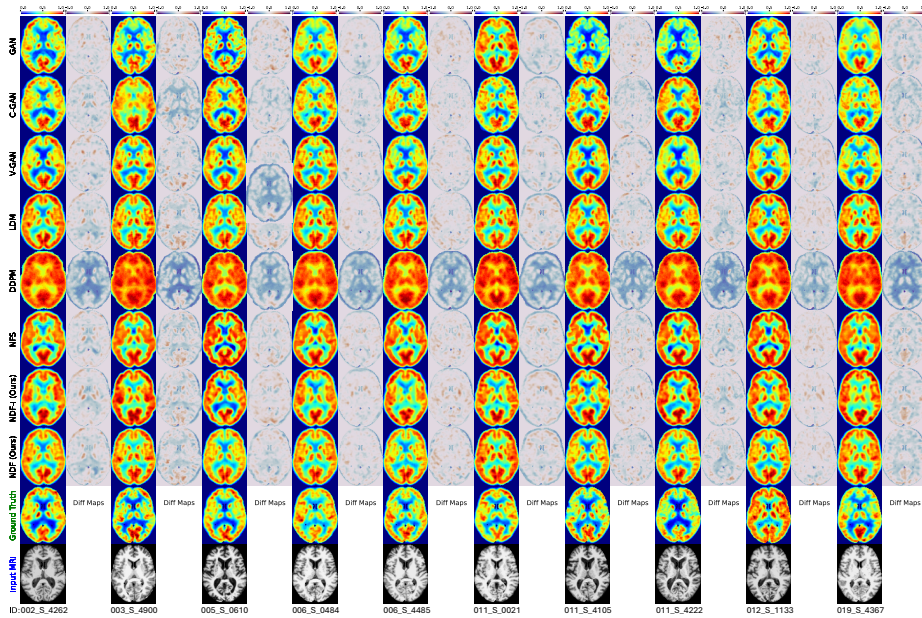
Test images of FDG-PET synthesized by 8 methods and difference (Diff) maps.
